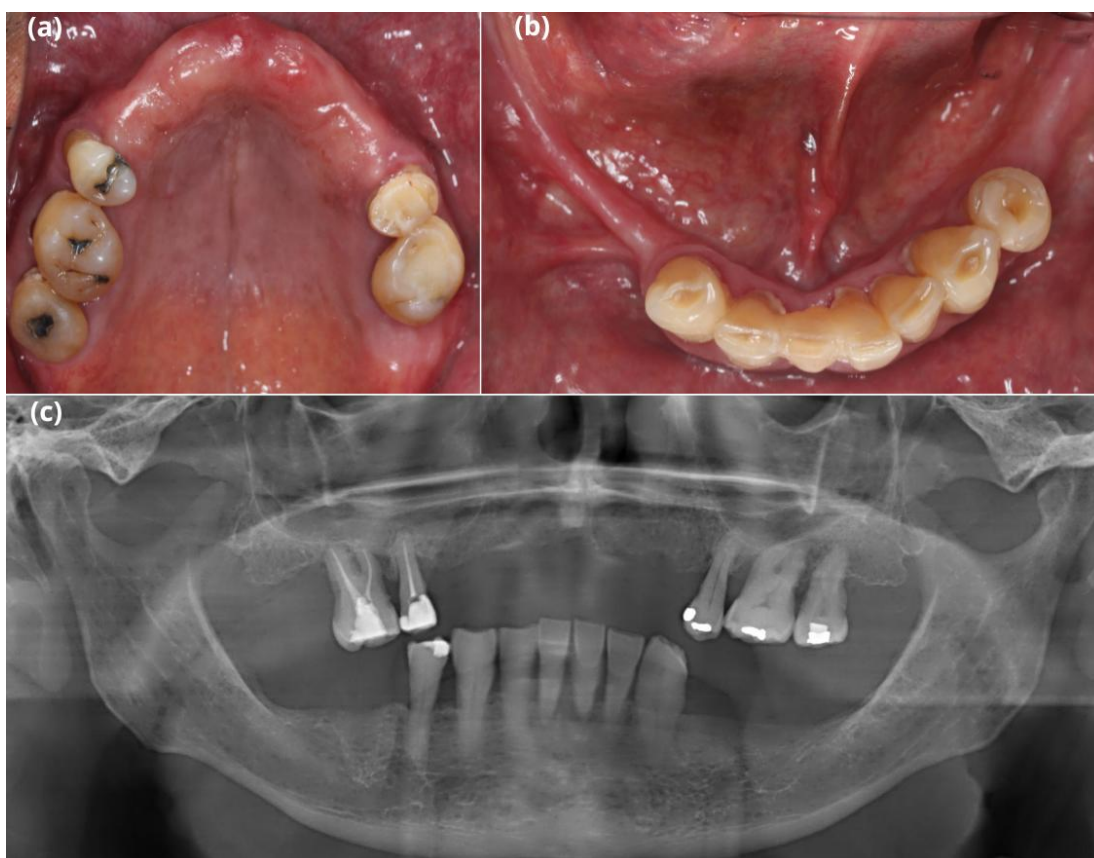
Initial condition case report 2. Clinical occlusal view (a-b). Panoramic radiograph (c).
